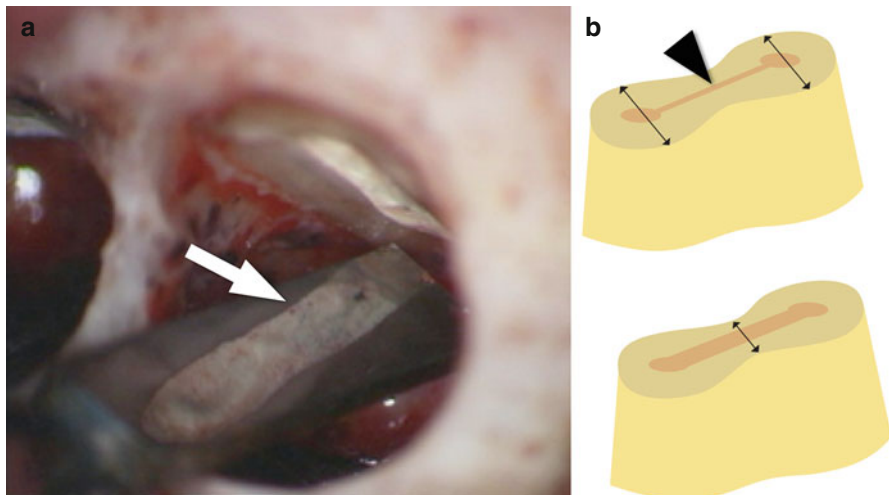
(a) Clinical view of high-power magnification of a prepared isthmus (*arrow*) in a mesial root of a mandibular molar. Only the complete but dentin-preserving preparation of an isthmus permits adequate disinfection. (b) After the main canals are retrogradely prepared, the isthmus (*arrowhead*) must be prepared and cleaned with either a round or potentially a blade-shaped ultrasonic tip. Care has to be taken to retain sufficient dentin wall thickness (*arrows*), specifically along the isthmus in roots with figure-eight cross-sections such as the mesiobuccal roots in maxillary molars and the mesial roots in mandibular molars
